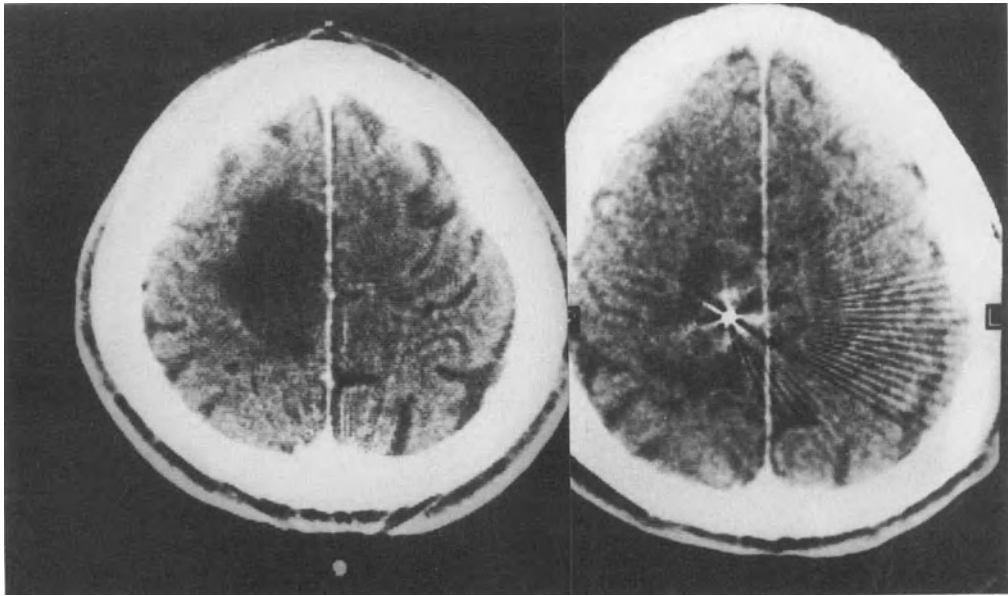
Stereotactic CT scan of a 21-year-old patient with a grade II fibrillary astrocytoma. (Left) CT revealed a relatively well-demarcated but extensive hypodense mass extending from the precentral to parietal area. (Right) CT performed three years after ^{125}I Curietherapy. The artifacts produced by the ^{125}I seeds can still be recognized. The central white matter still shows a hypodense area, but the sulci are enlarged. We detected no evidence of recurrent astrocytoma.
